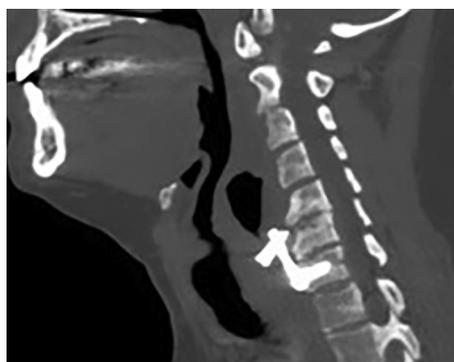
Cervical spine CT showing a displaced screw at C6.
